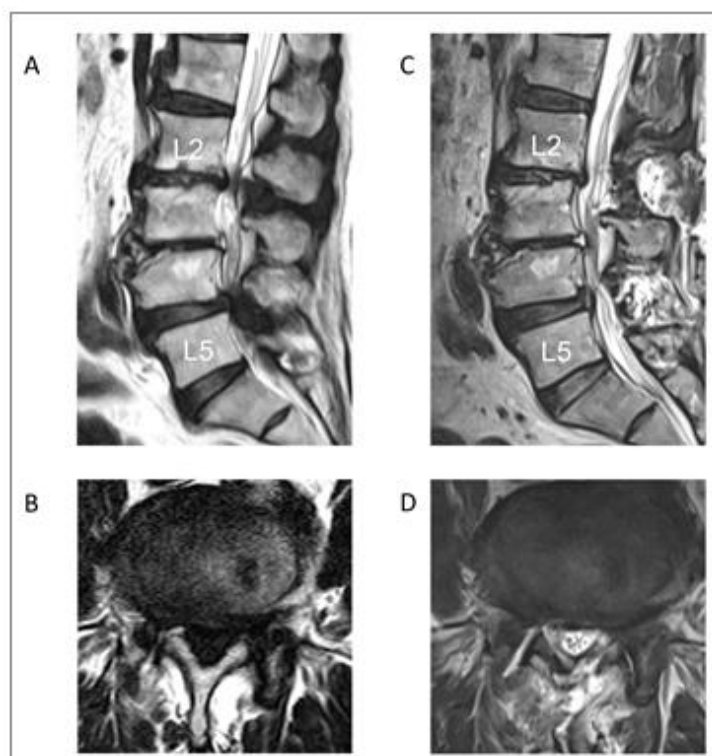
MRI findings of the lumbar spine before and after nerve decompression. T2-weighted images.
